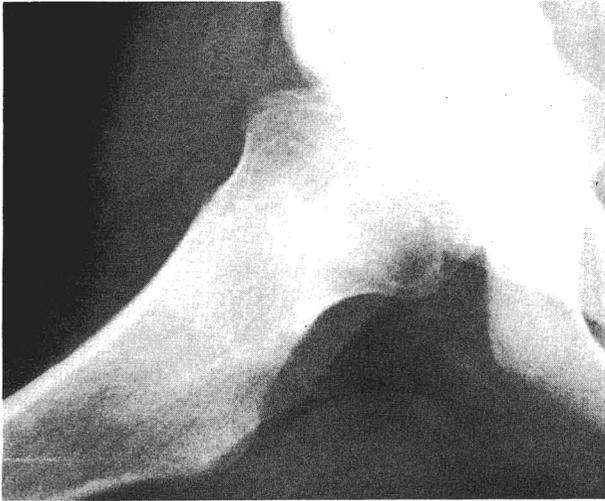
Traumatic exostosis in a boy, aged 18 years. Five years before he sustained multiple injuries. He complained of much pain and stiffness in the hip, but radiographs were normal. He later shows this traumatic exostosis which limited movement and was excised.
